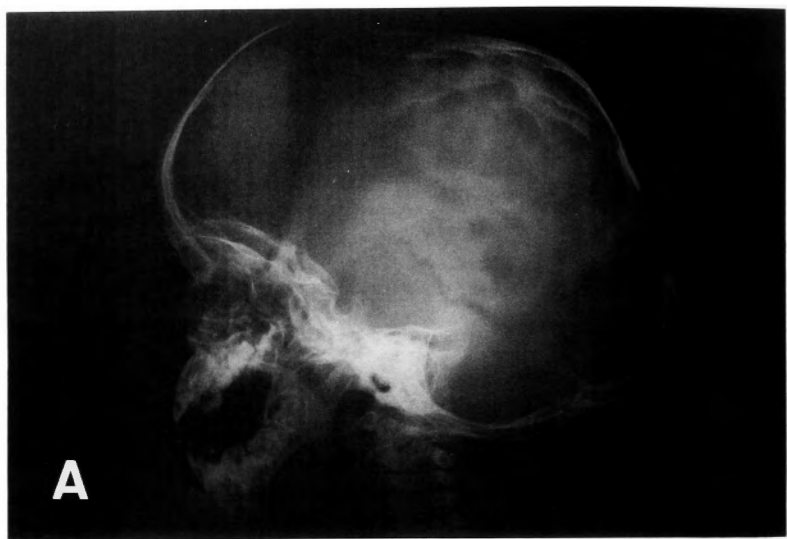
Plain skull X-ray shows a diastasis of the coronal and lambdoid sutures (A), synostosis of the sagittal suture (B) and digitiform impressions.
